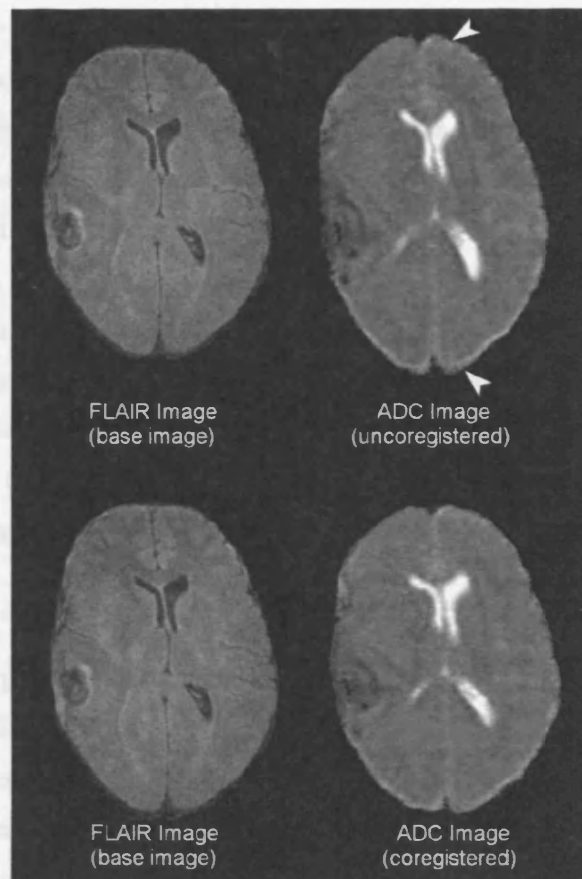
Top image pair show FLAIR and ADC image which are unaligned, the ADC image has different contrast and has distortions particularly in the frontal and occipital regions (arrowheads). These distortions make the brain appear elongated in the antero-posterior direction. The distortions are common in EPI sequences and are due to field inhomogeneities caused by the air tissue interface around the air sinuses. The lower image pair shows the effect of a non-rigid coregistration on the ADC Image. The images are aligned and the distortions greatly reduced.
